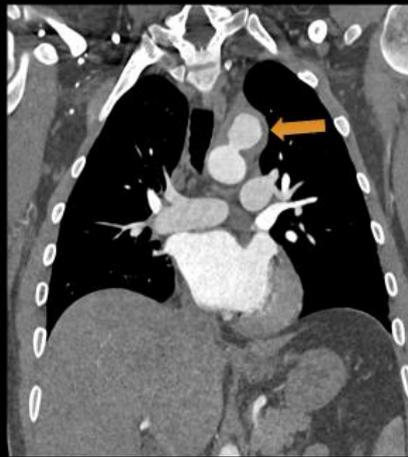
A CT aortic angio thoracic arch saccular aneurysm just distal to the origin of left common carotid artery
